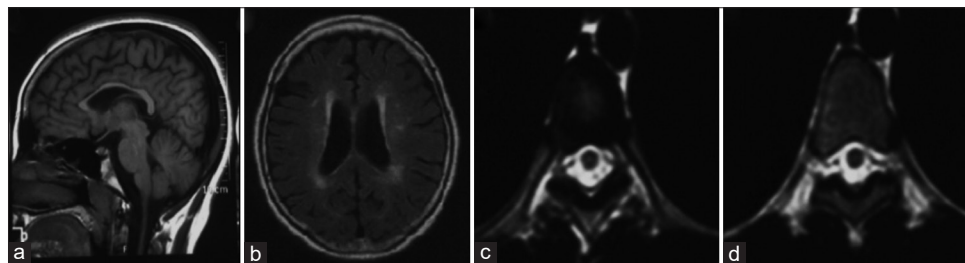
MRI brain shows (a) thinning of corpus callosum in T1W sagittal view, (b) periventricular hyperintensities in T2W/FLAIR axial image in a patient with SPG 11 mutation and MRI dorsal spine shows (c and d) thinning of dorsal cord in T2W axial images in a patient with SPG 7 mutation
